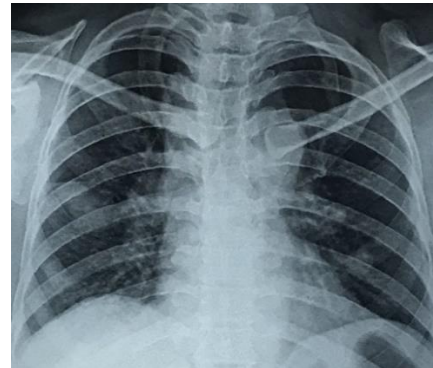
chest x-ray posteroanterior view showing right middle zone lobulated mass and left paracardiac nodular opacity
